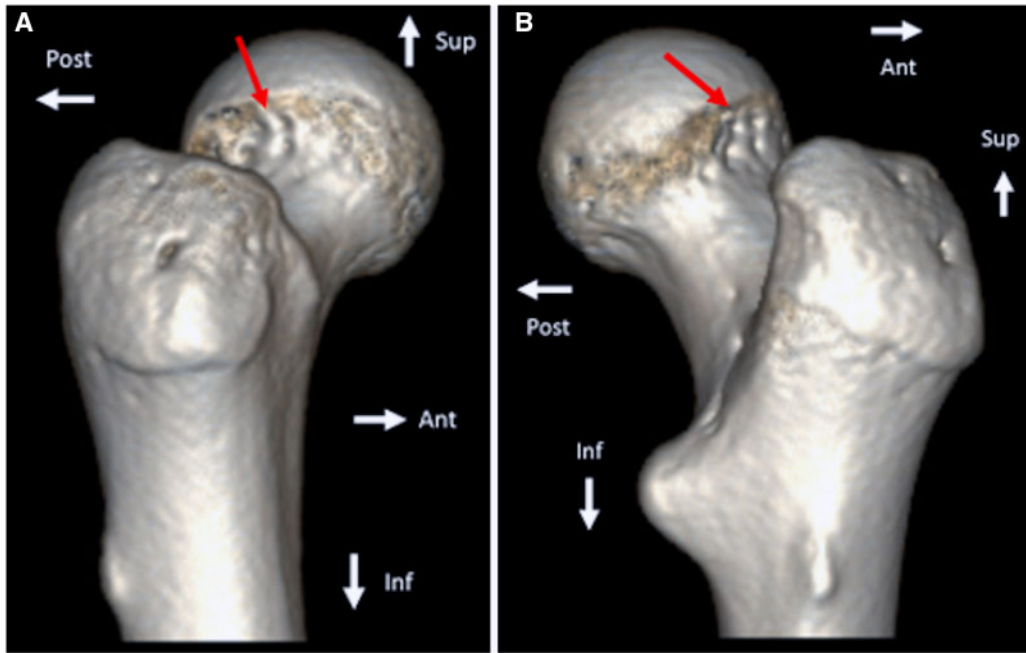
Three-dimensional computed tomography (CT) scan of right proximal femur of 17-year-old female ballerina with cam morphology. Anterolateral view (A) and posterolateral view (B). Ant (anterior); post (posterior); sup (superior); inf (inferior). Red arrow indicates four foramina for the lateral ascending vessels, the terminal branches of the medial femoral circumflex artery, the primary blood supply to the femoral head.
